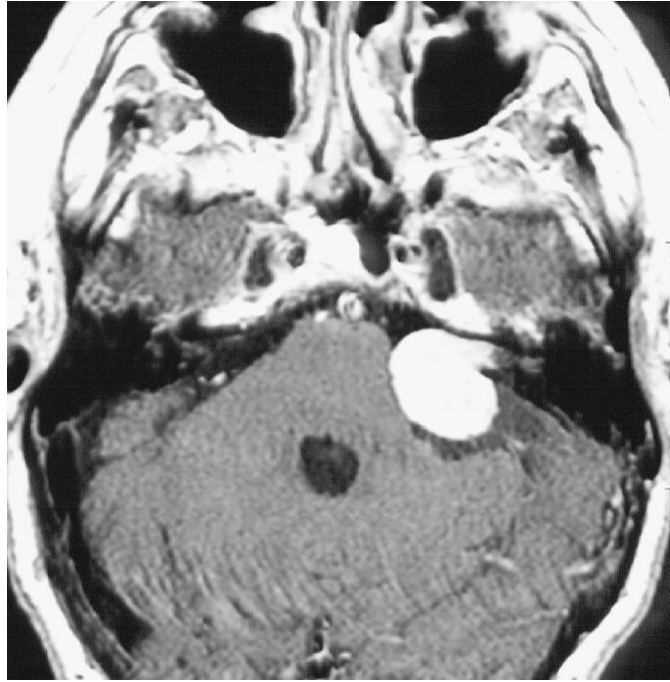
Acoustic Neuroma. Postcontrast T1-weighted axial image demonstrating an intense contrast enhancing extraaxial mass at the left cerebellopontine angle close to the left internal auditory canal (IAC) consistent with an acoustic neuroma.
